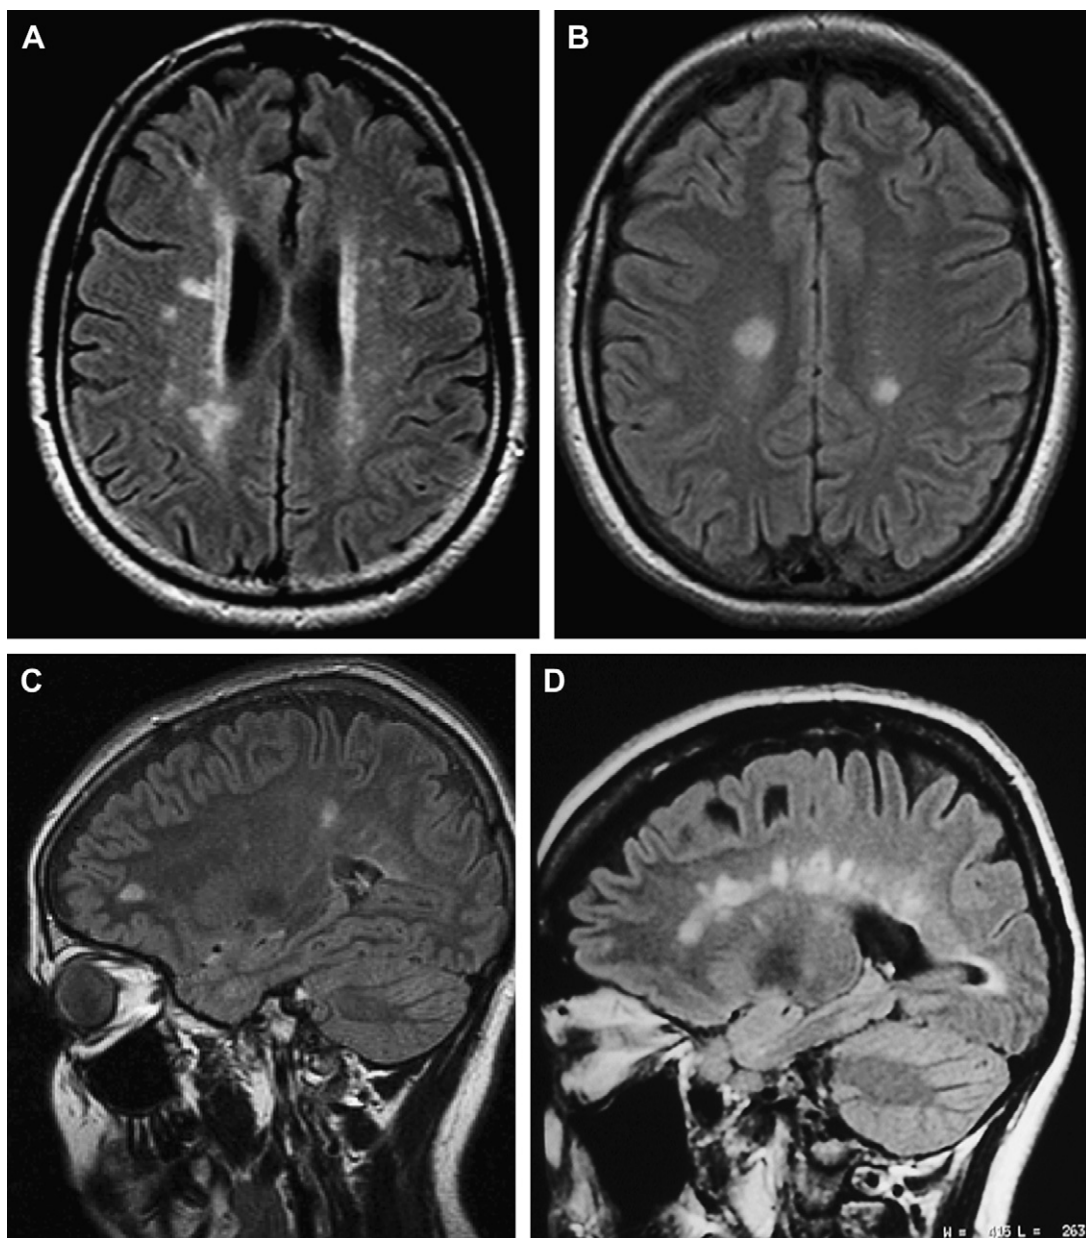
MS: different imaging features. (A, B) Axial fluid-attenuated inversion recovery (FLAIR) shows typical appearance of deep WM plaques like multiple hyperintense lesions in subcortical and cerebral deep WM, mostly ovoid in shape. (C, D) Sagittal FLAIR shows demyelinating plaques along the margin of lateral ventricles and the corpus callosum, with the typical radial arrangement, called Dawson fingers.
